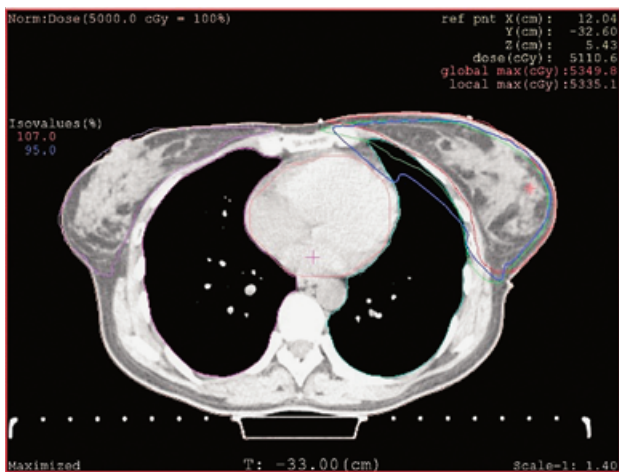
CT sagittal slice from XiO Treatment Planning System
